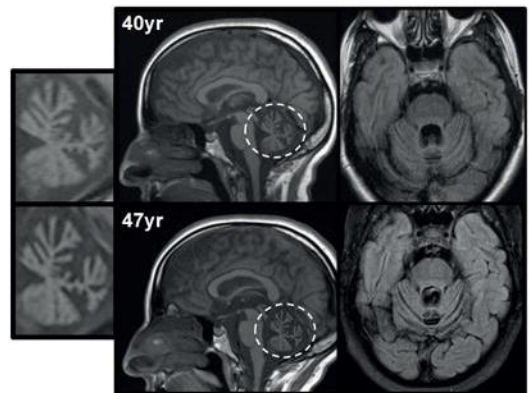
MRI examination of XD1 patient brain at the age of 40 (top) and 47 (bottom). Adapted from (Hoch et al., 2017).
